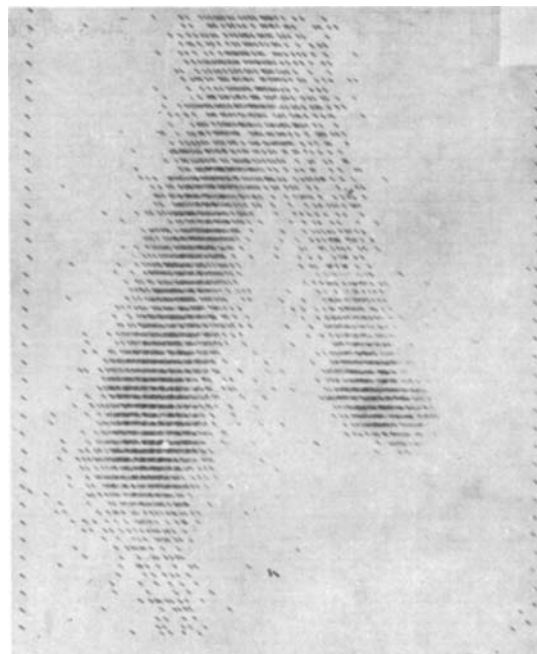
Bladder cancer, stage T3N1M0. Lymphoscintigram shows tumour on the left lateral wall, collection of isotope in the area of iliac lymph nodes on the left
